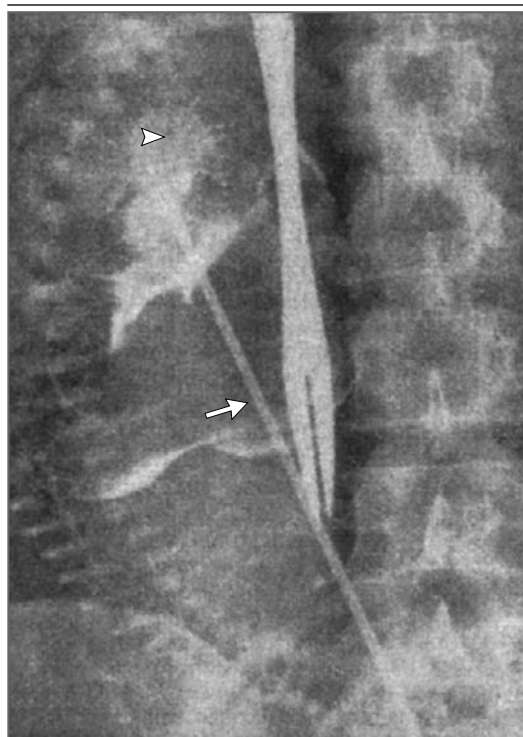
Radiographic Image of the First Successful Intrauterine Fetal Transfusion Performed under Fluoroscopic Guidance by Liley, in 1963.
